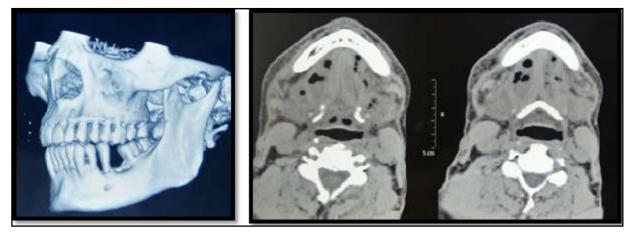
CT (Brain + C-Spine) Images; A. The lower left first molar is absent showing bony erosion while the first and second premolars appear periodontally compromised. B. Right retromolar and parapharyngheal abscess with air foci seen
